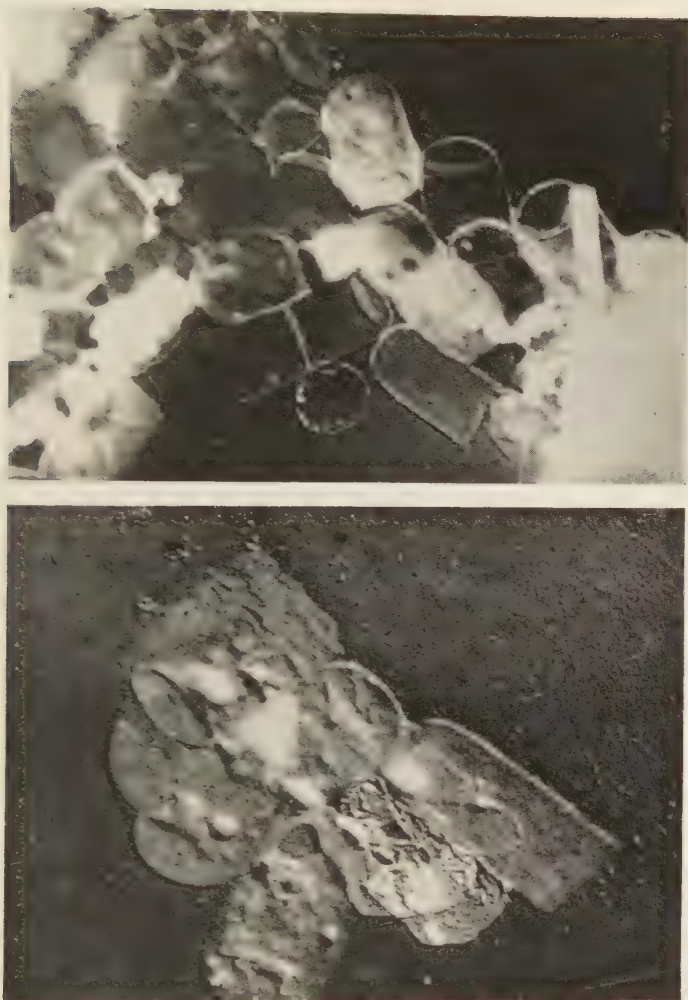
The cells shown in FIGURES 1 and 2 after 5 minutes of ultrasonic treatment.
